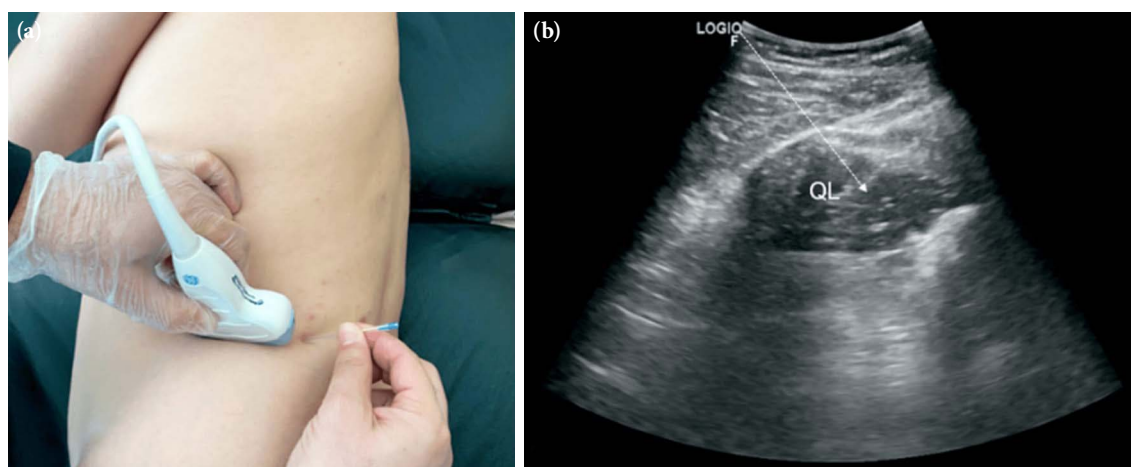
Ultrasound-guided dry needling technique for the quadratus lumborum muscle: probe placement, needle position and ultrasound image; (a) probe placement and needle position, (b) ultrasound image of the quadratus lumborum muscle.
